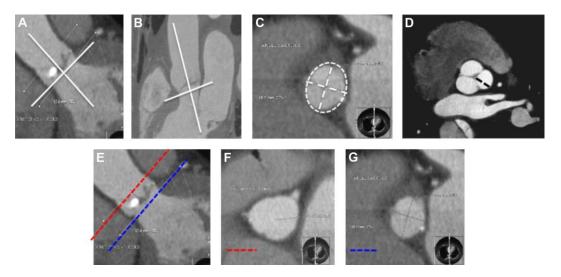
Methodology for assessing AoA size, aortic leaflet size and coronary artery ostia height using MDCT. Measurements of AoA (Panel A-C): AoA is defined as a virtual ring formed by joining the basal attachments of aortic valve leaflets. For each AoA, maximum diameter, minimum diameter and area (white dot line) were measured in an orthogonal plane on the center line of the aorta obtained in oblique-coronal and oblique-sagittal views, respectively. Measurement of leaflet size (Panel D): the distance between the basal attachment and the apex of the leaflets (black dot line) is determined. Measurement of coronary ostia height (Panel E-G): a coronal view of the ascending aorta (E) and two short axis at the level of the left main coronary ostium (red line) and AoA (blue line) are obtained. The distance between these two lines corresponds to the coronary ostium height. AoA: aortic annulus; MDCT: multidetector computed tomography.
